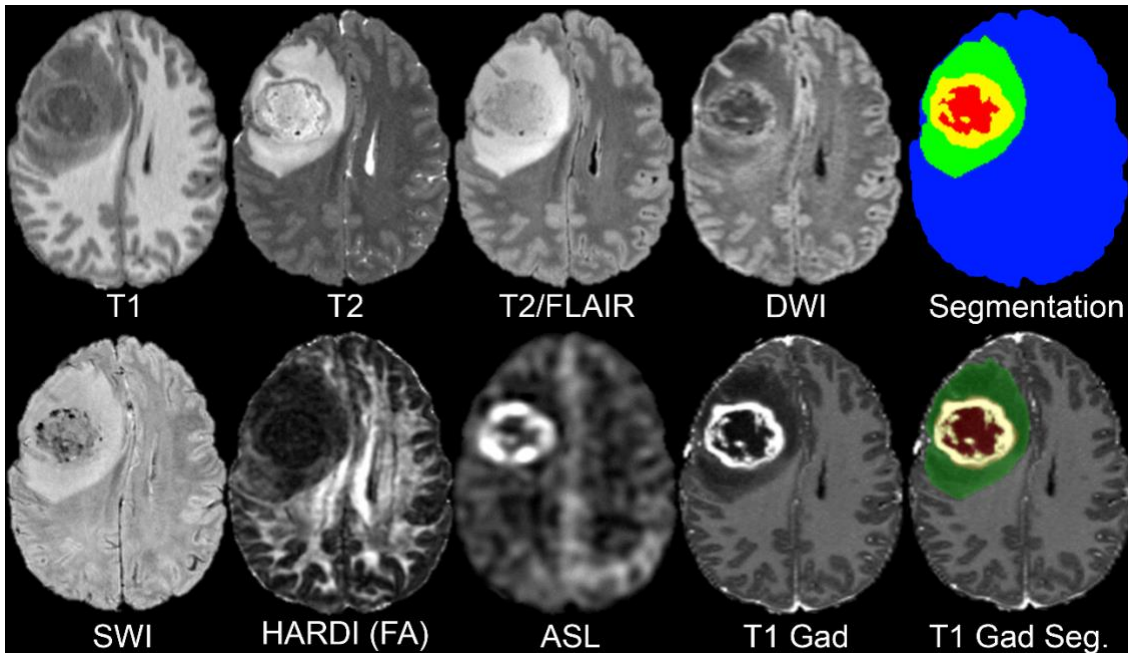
Representative multimodal MR images from a single case in the UCSF-PDGM dataset. T1: T1-weighted pre-contrast, T2: T2-weighted, T2/FLAIR: T2-weighted FLAIR, DWI: isotropic (trace) diffusion weighted image, SWI: susceptibility-weighted image, HARDI (FA): fractional anisotropy derived from HARDI data, ASL: arterial spin labeling perfusion, T1 Gad: T1-weighted post-contrast, Segmentation: multicompartiment tumor segmentation (blue = brain, green = FLAIR abnormality, yellow = enhancing tumor, red = necrotic core), T1 Gad Seg.: tumor segmentation semitransparent overlay on T1-weighted post-contrast image.
